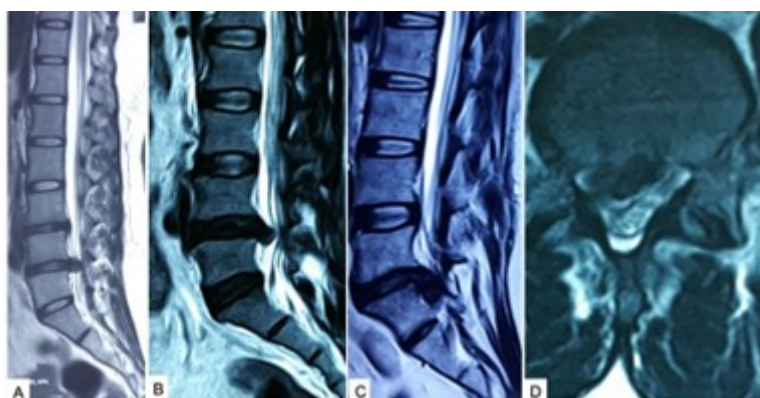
(A,B) MRI of lumbosacral spine (T2W sagittal images) showing PLID at L4 and 5. (C,D) MRI of lumbosacral spine (T2W sagittal and axial images) showing, respectively, PLID at L5 and S1 (left). Source: Figure by authors.
